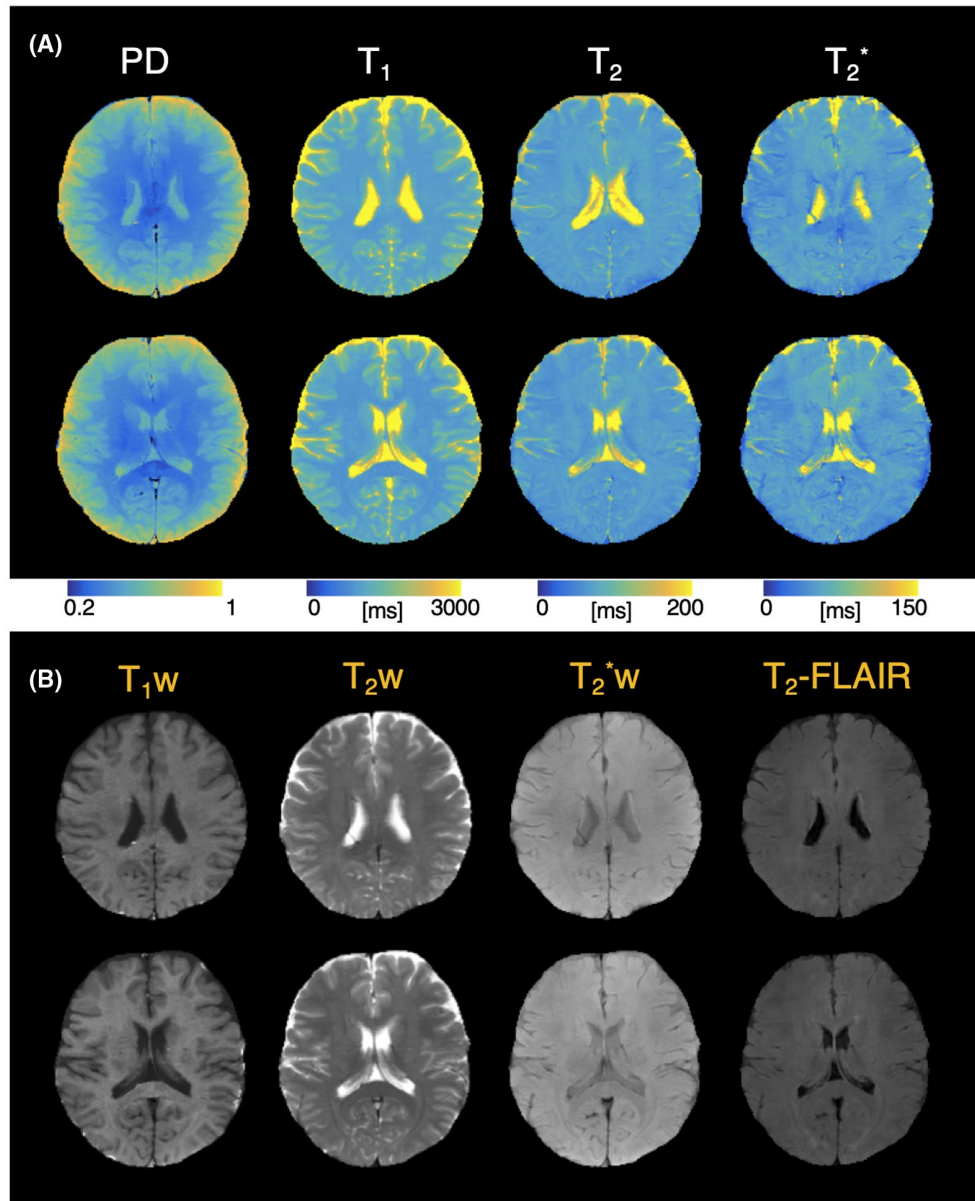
A, Quantitative parameter maps from two slices from protocol C, a multi-shot acquisition ($R = 8$, 3 shots). B, Synthetic weighted contrasts derived from parameter maps of both slices, showing T_1w , T_2w , T_2^*w , and T_2 -FLAIR images
